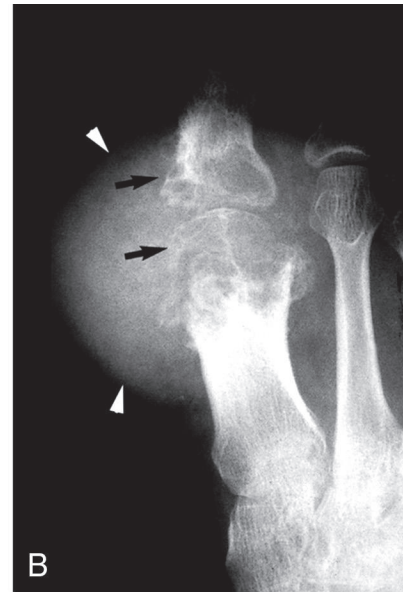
A, AP radiograph of the foot of a patient with gout. Note the erosions with sharp margins, the overhanging edge in the metatarsophalangeal joint of the great toe (arrow), and a soft-tissue mass around the first metatarsal consistent with a deposit of sodium urate (arrowheads). B, AP radiograph of the great toe of a patient with advanced gout. The black arrows indicate large, well-margined erosions on both sides of the metatarsophalangeal joint, and the white arrowheads indicate a large soft-tissue mass. These findings are consistent with advanced gout.
